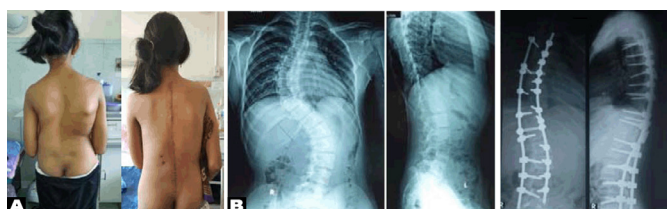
Fifth patient case presentation: clinical picture (A) and X-ray (B) pre- and post-operative.
